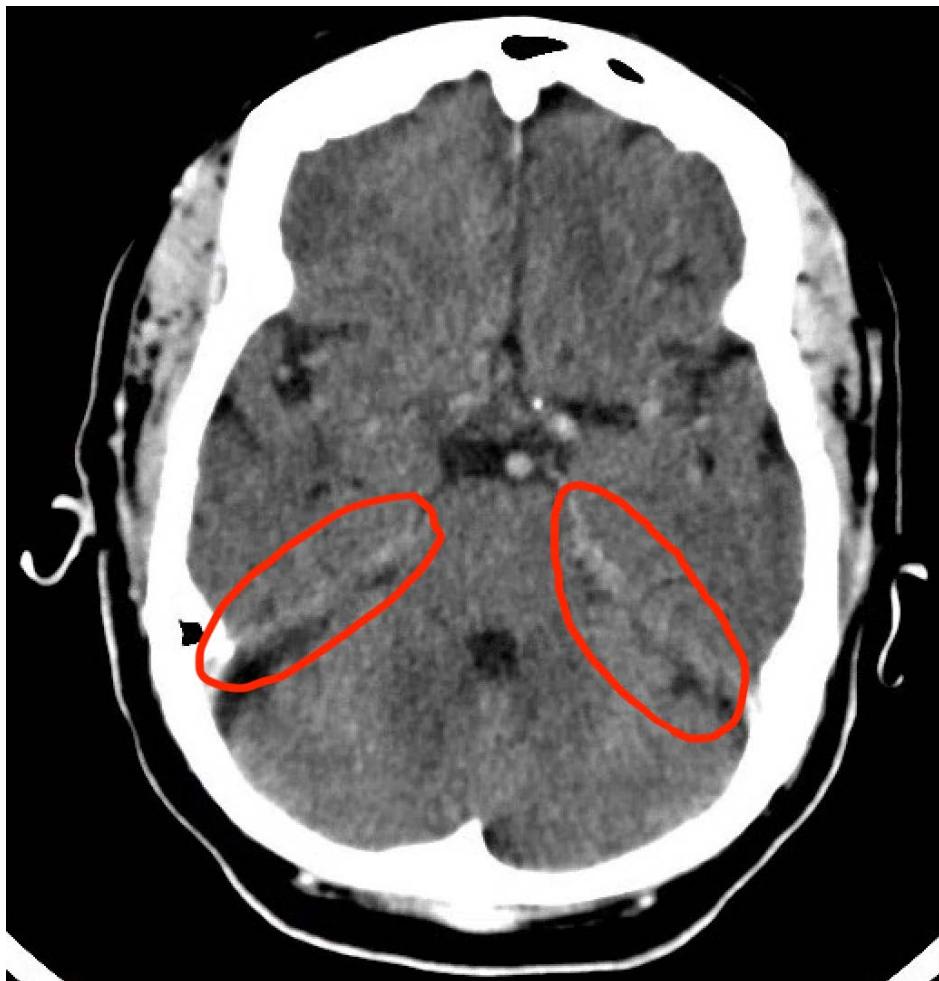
CT Brain demonstrating bilateral subtle subarachnoid contrast uptake (circled)
